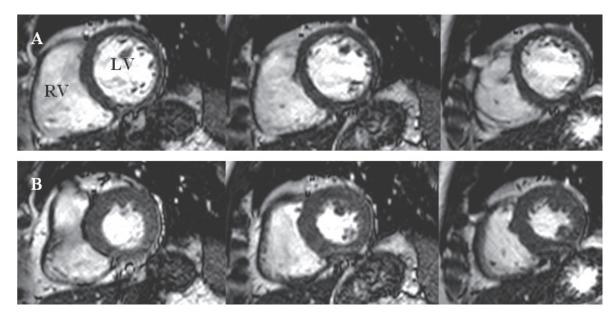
Gradient echo CINE MRI images on short axis view reveal moderate RV systolic function with mild global hypokinesia (RVEF = 45.0%, normal = 54-78%). Series A: diastolic phase; Series B: systolic phase
